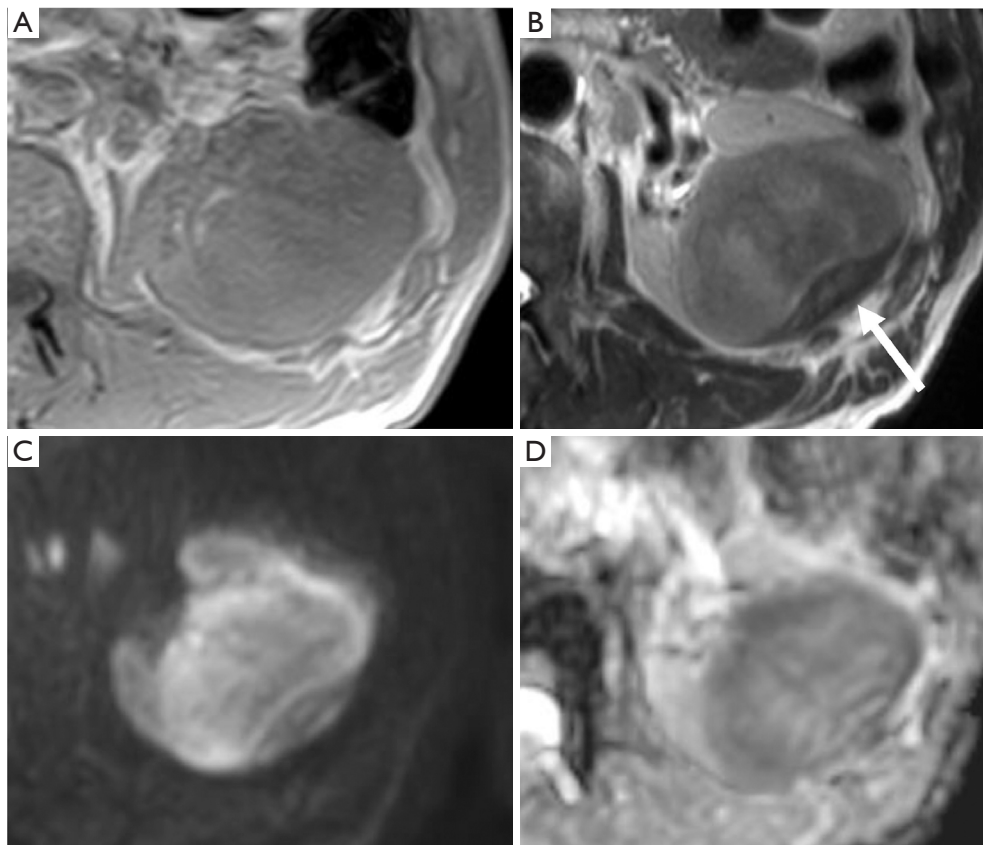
Magnetic resonance imaging of a left renal mass demonstrates (A) T1 isointense, (B) T2 mildly heterogeneous hypointense signal and mild diffusion restriction with (C) mildly increased signal on DWI and (D) low ADC. DWI, diffusion weighted imaging; ADC, apparent diffusion coefficient. Reproduced from Yamamoto *et al.* (26).
